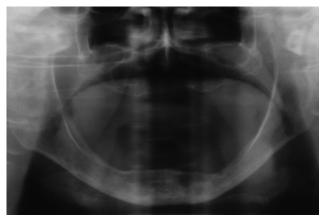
Preliminary panoramic radiograph of a fully edentulous patient with extremely atrophic posterior mandible. The closeness of the alveolar nerve to the posterior ridge can be noted.
